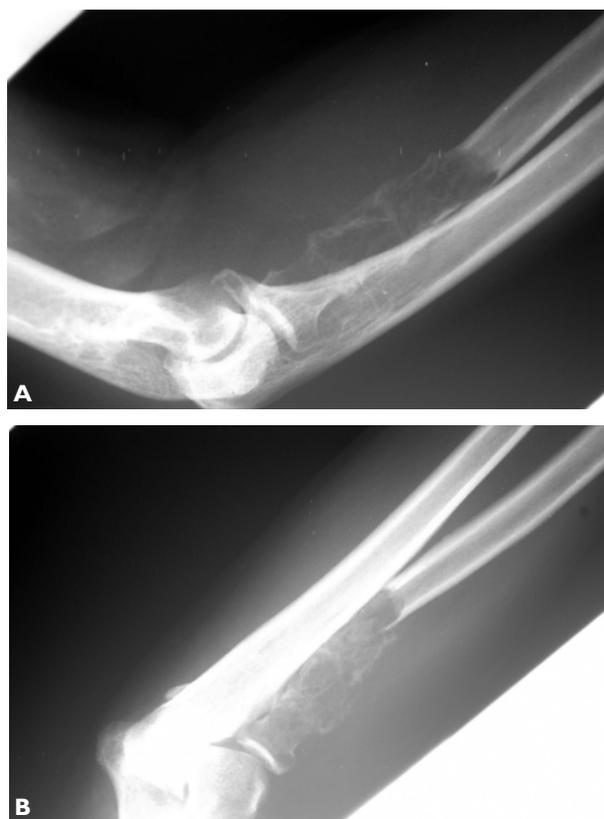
Radiographs of the case patient's right elbow. (A) Lateral view. (B) Anteroposterior view.
